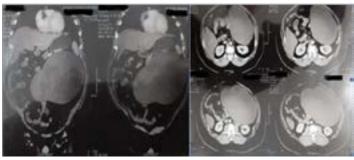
CT preoperative of the huge cyst
